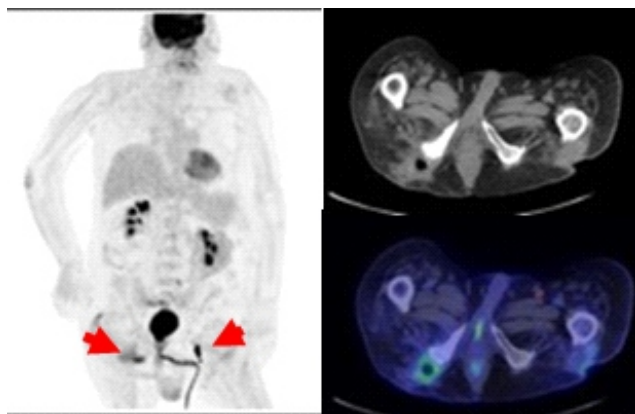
Tetraplegic 53 year old patient with recent onset of right gluteus weal. Computed tomography: fistula in the right gluteal region and signs of osteomyelitis. Fluorine-18-FDG PET/CT: typical ^{18}F -FDG uptake in peri-articular soft tissues of the right coxo-femoral joint in the right gluteal region and in inguinal lymph nodes.
